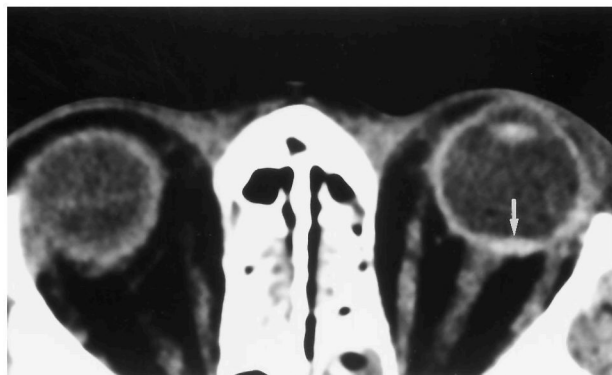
Case 3: 35-year-old woman with severe closed head injury after being struck by a car. Two months later a left visual field deficit was noted during admission for shunt revision. Fundoscopy revealed retinal hemorrhage in the temporal pole and old vitreous blood in the left eye. A CT scan obtained on the day of the trauma revealed a hyperdense crescent (*arrow*) in the temporal retinal surface adjacent to the optic nerve corresponding to the site of hemorrhage on fundoscopy.
